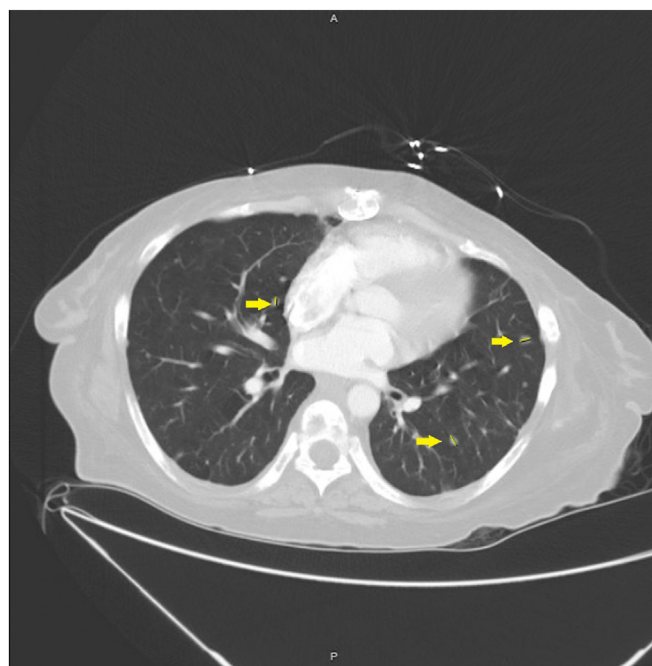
CT scan of the chest demonstrated multiple pulmonary nodules (yellow arrows). CT = computed tomography.
